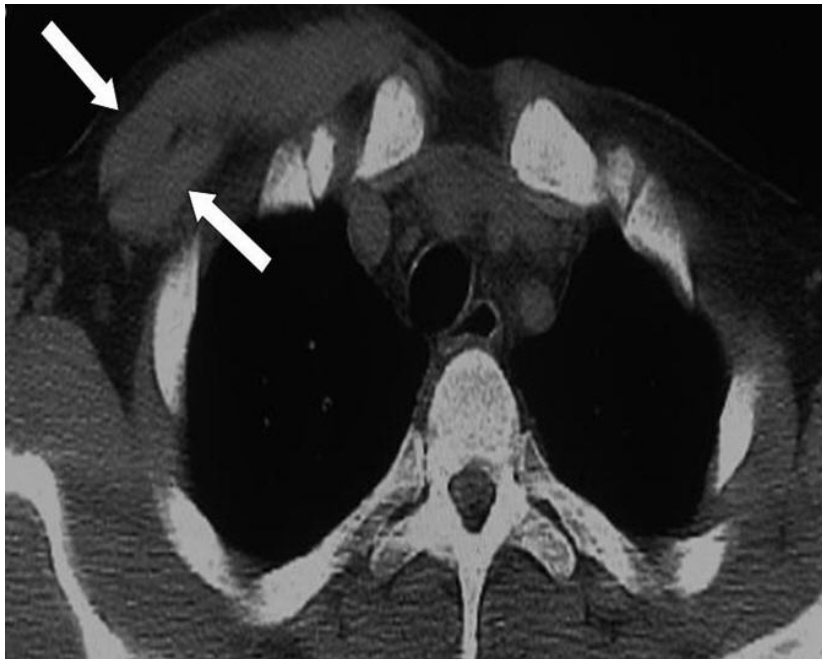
Axial plain CT scan shows pectoral muscles on the right chest (arrows) but pectoral muscles are absent on the left side
